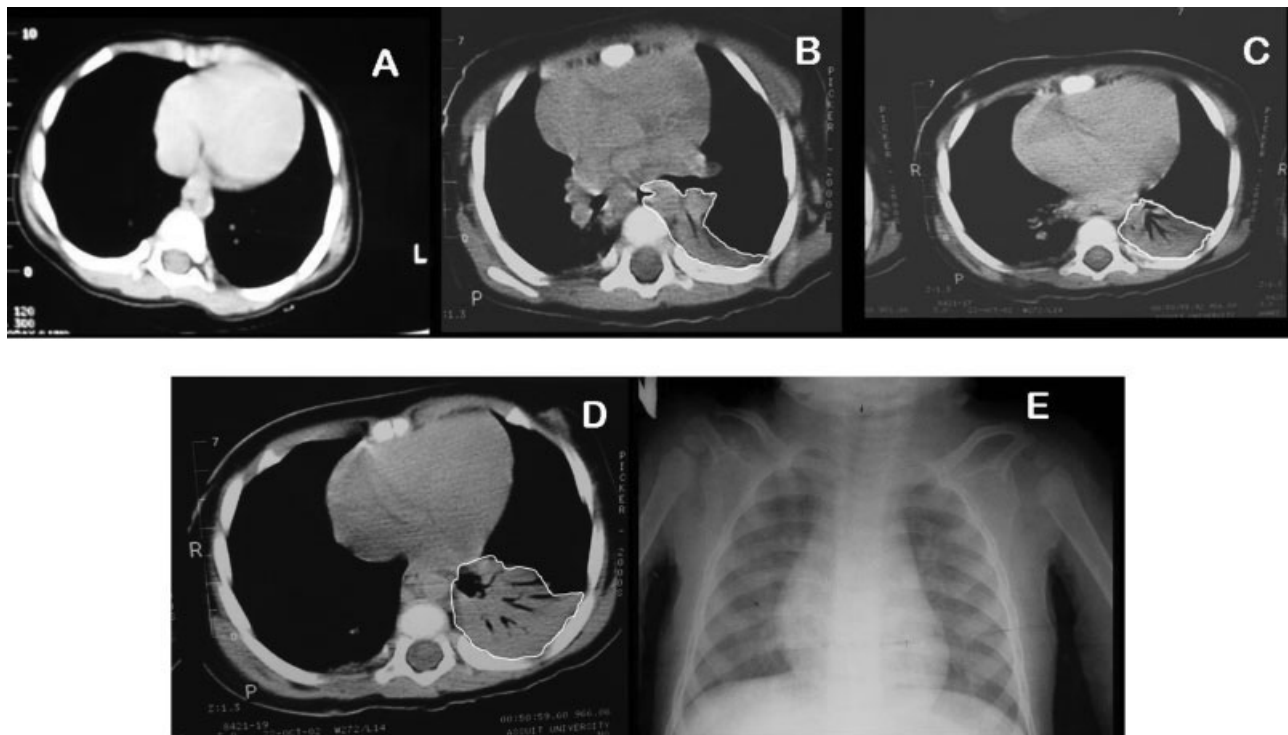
Left sided pulmonary collapse complicated by postoperative pneumonia. Age: 18 months. Anesthesia time: 360 minutes. (A) Before induction, (B) Early postoperative. Atelectatic area = 4.19 cm², (C) Third day postoperative. Atelectatic area = 9.69 cm², (D) Sixth day postoperative. Atelectatic area = 12.65 cm², (E) Corresponding chest. X-ray failed to show either collapse or consolidation.
